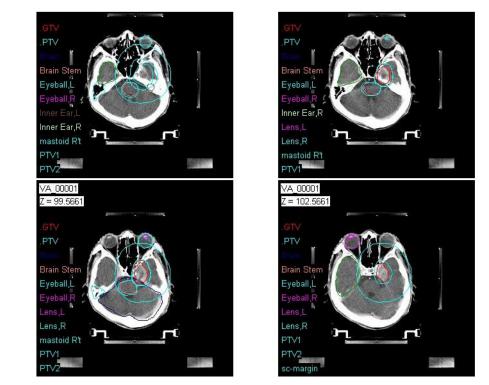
Display Window showing CT diagnostic images overlaid with isodose curves obtained from the IMRT TPS. The contours show percentage dose values calculated for critical structures that have been outlined prior to computing the treatment plan.
